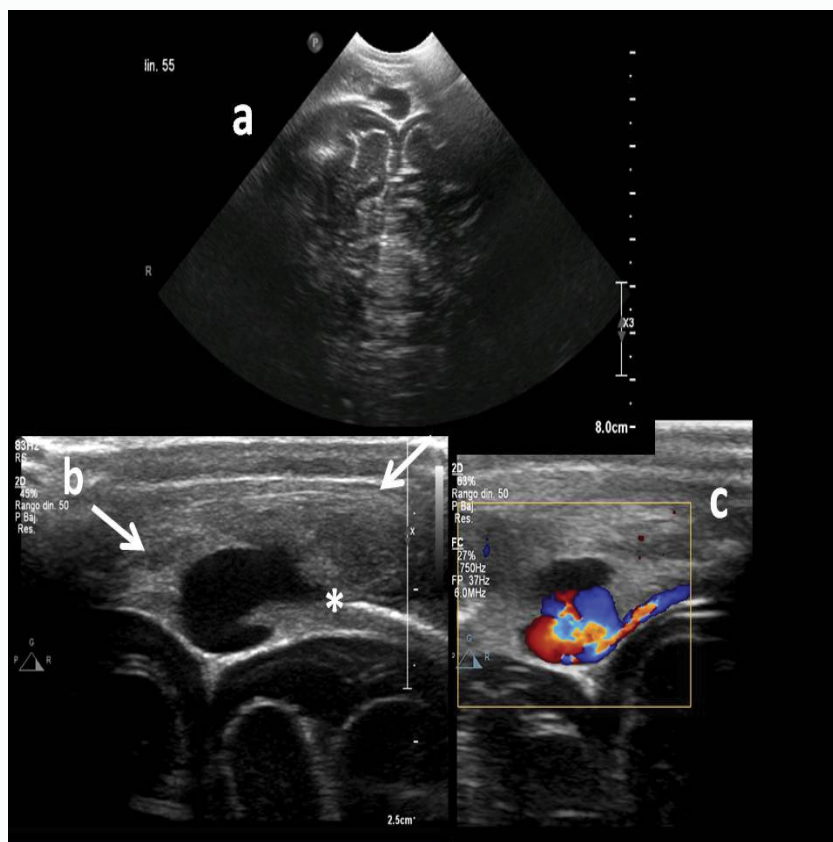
Head ultrasound: Brain coronal plane (a), magnified image (b) showing an enlargement in soft tissues (arrow) associated with a hypoechoic lesion that introduces through a cranial diploic effect (*). Doppler study (c) demonstrates the presence of flow in the mentioned structure.
